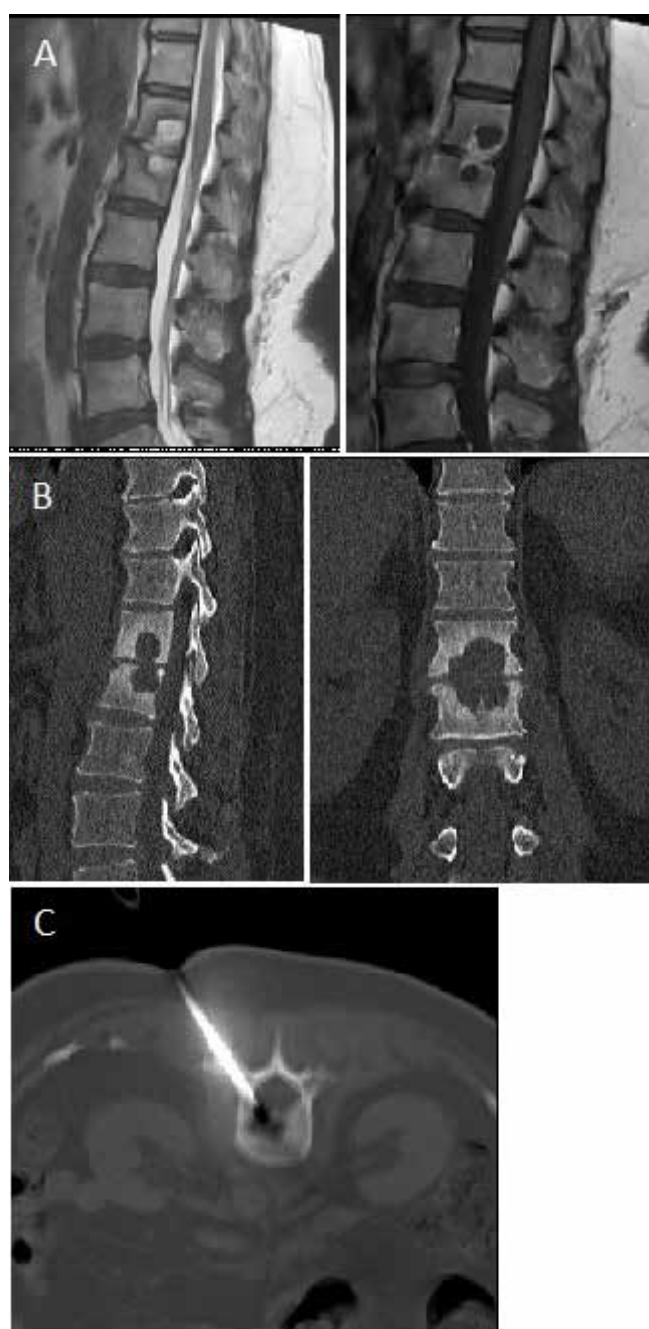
(A) MR imaging (B) CT imaging (C) CT-guided lesion aspiration
